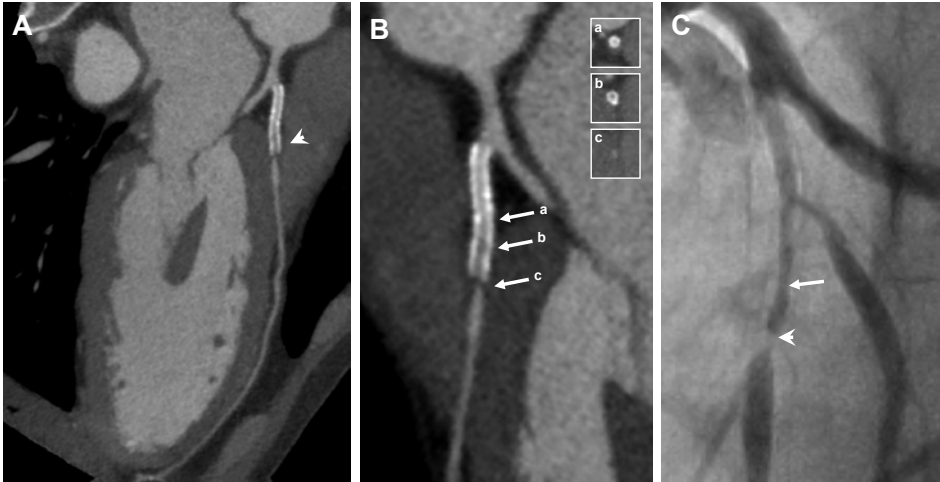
320-row CTA reveals patency of three adjacent, partially overlapping drug-eluting stents (from proximal to distal: Endeavor, 4.0 mm x 24 mm; Promus, 4.0 mm x 23 mm; Endeavor 4.0 mm x 15 mm) in a venous bypass graft of a 86 year-old male patient. Multiplanar reconstructions in panel A and panel B (using a sharp convolution kernel) reveal stent patency (arrowheads). An invasive angiogram (Panel C) confirms the absence of significant in-stent hyperplasia (arrowhead).
